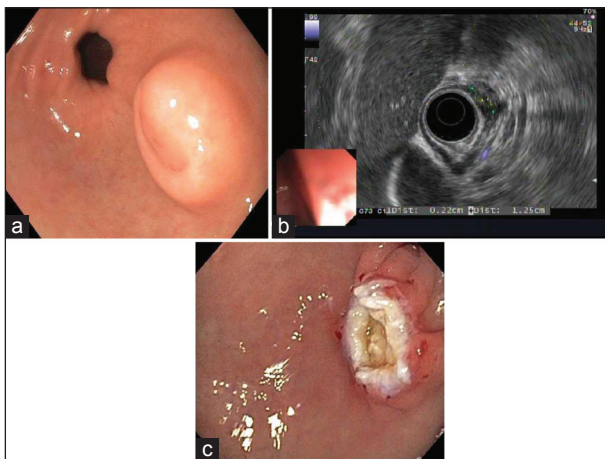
Pancreatic rest. (a) Endoscopic view; (b) Endoscopic ultrasound (EUS) view; (c) Lesion after endoscopic submucosal resection
